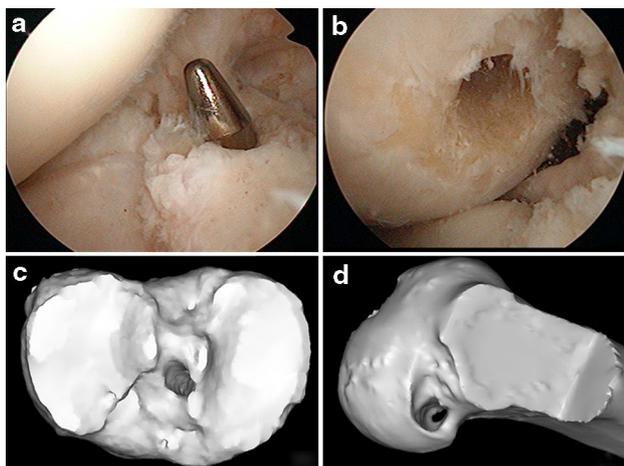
Anatomic single-bundle ACL reconstruction in a right knee. a The tibial tunnel is located in the centre of the native ACL insertion site (arthroscopic view). b The femoral tunnel is located in the centre of the femoral insertion site (arthroscopic view). c and d Tibial and femoral tunnel position on corresponding 3D CT scan
